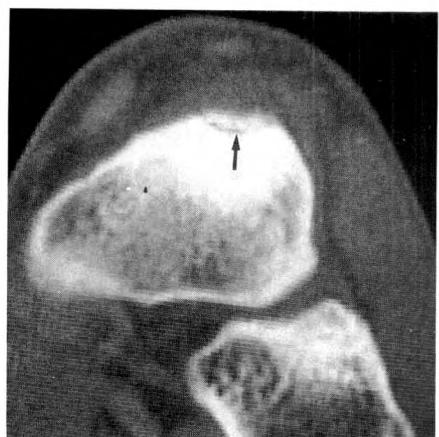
Partial linear fracture of right navicular bone in a 22-year-old heptathlete who had signs and symptoms for 1 month. Axial CT scan shows a Y-shaped fracture with an undisplaced small bone fragment in normally sclerotic dorsal rim of navicular bone.
